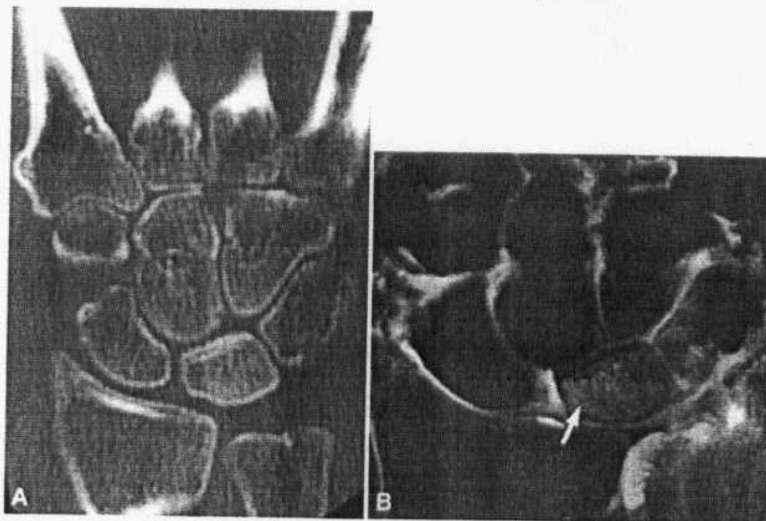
Stage II Kienböck's disease with (A) increased lunate density (sclerosis) on coronal reformatted CT scan and (B) corresponding marrow hyperintensity on fast STIR coronal image(Quoted from Stoller and Brody, 1997).
